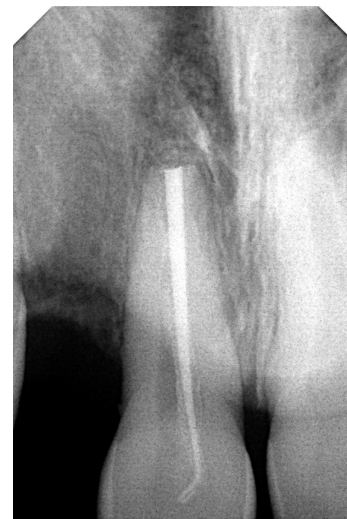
Targeted X-ray of tooth 11 during the diagnostic process
